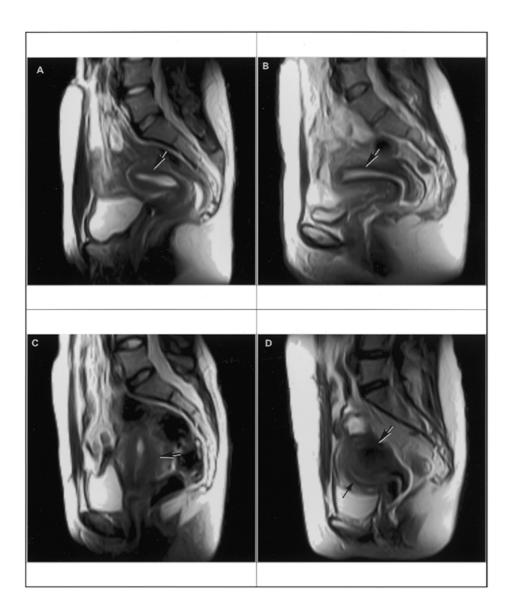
T2-weighted (2500/80 ms [TR/TE]) spin echo midline sagittal sections of uteri of women in reproductive years. (A and B) Normal myometrial zonal anatomy: although the low signal-intensity junctional zone (arrow) is regular in both cases, it appears distinctly thinner in B. The clinical significance, if any, of a very thin junctional zone (<3 mm) in the absence of exogenous steroid treatment is unknown. (C) Junctional zone hyperplasia: the inner myometrial zone is not only irregular but there is also diffuse thickening of this layer affecting predominately the posterior myometrial wall (arrow). (D) Large focal adenomyoma affecting the entire posterior uterine wall (fat arrow). Note that the junctional zone (thin arrow) is thin and regular, indicating that diffuse and focal adenomyosis may have distinctly different aetiologies.
